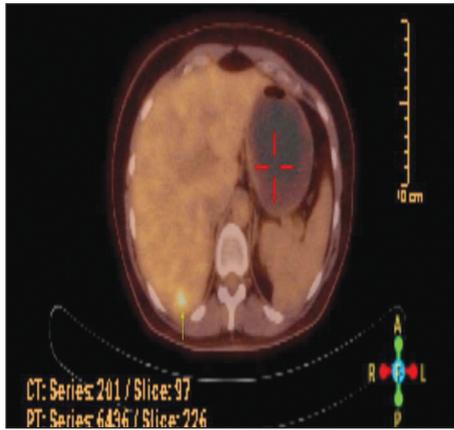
A hypermetabolic lesion (maximum standard uptake values: 4.98) in segment 7 of the liver on positron emission tomography/computed tomography.
